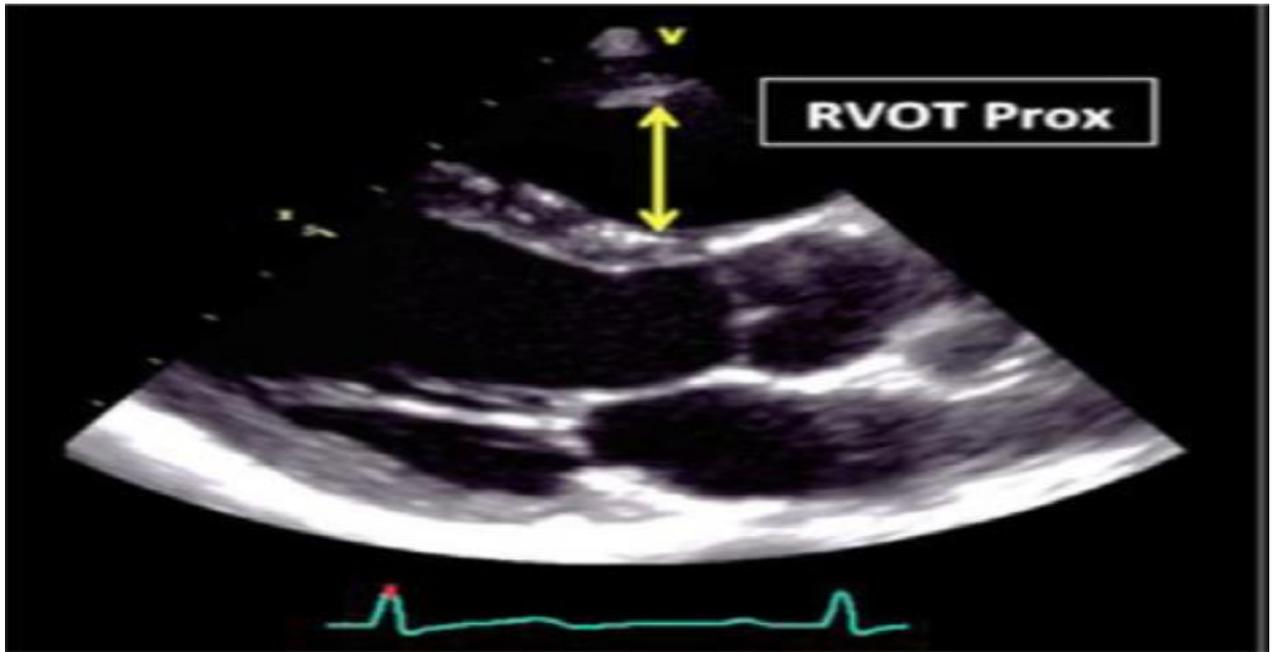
RV outflow tract diameter from the parasternal long-axis view (RVOT-PLAX) (Rudski et al., 2010)
